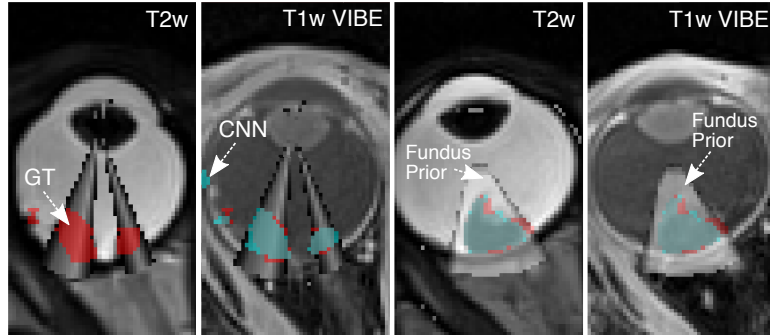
Fundus Probability Prior Map: Two examples of the *Fundus Prior* probability map obtained in section 5.2. The light blue areas are the result of the automatic segmentation in the 3D MRI. The cones do not always represent the whole tumor area as the Fundus camera field of view is rather limited.
